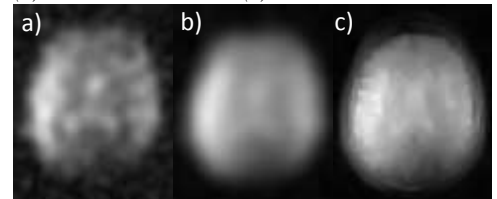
¹⁷O MR images reconstructed with KB gridding without (a) and with Hanning window and with proton constraint (c). TA = 10 min
